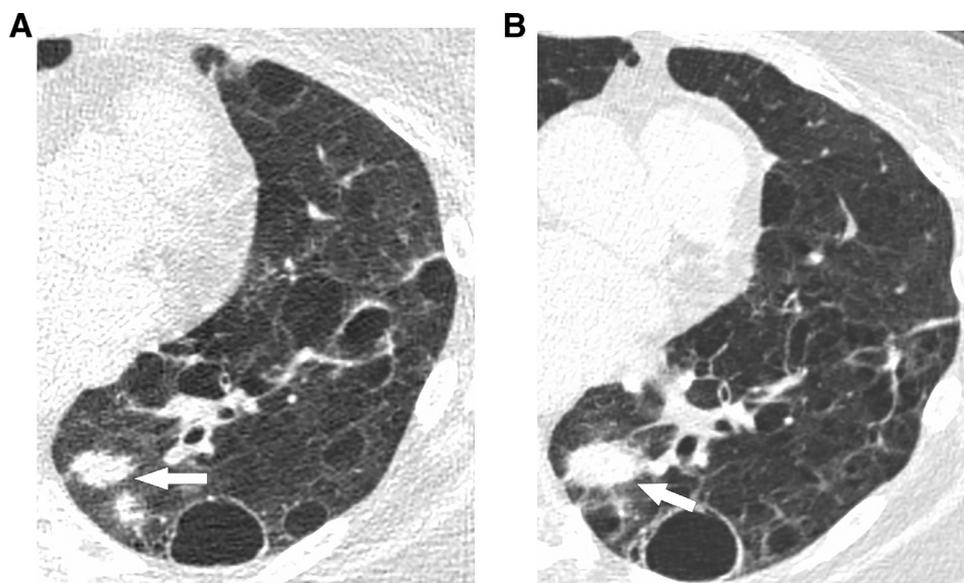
A 66-year-old female with SS and MALT lymphoma. (A) HRCT image shows multiple thin-walled perivascular cysts and two large left lower lobe nodules (arrow). HRCT image 3 months later shows growth of the dominant nodule (arrow), confirmed on needle biopsy to be lymphoma. MALT, mucosa-associated lymphoid tissue.
